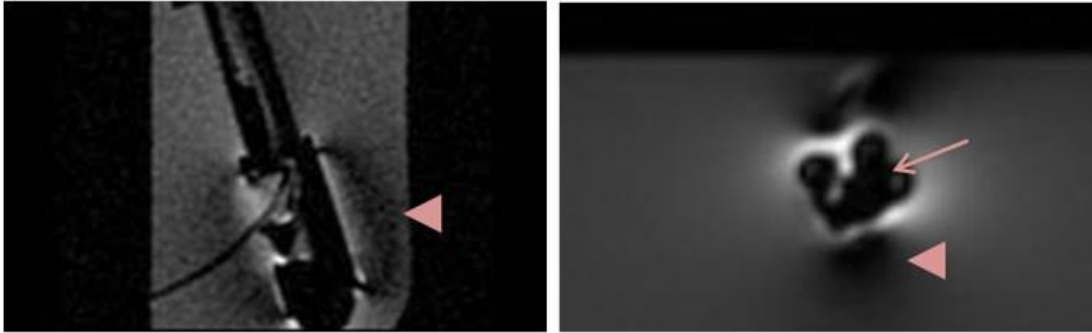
Sagittal (l) and Axial (r) MRI of duodenoscope tip immersed in water. Limited susceptibility artefacts are visible (arrow); the dark areas behind the tip are due to the tip coil (arrowheads).
